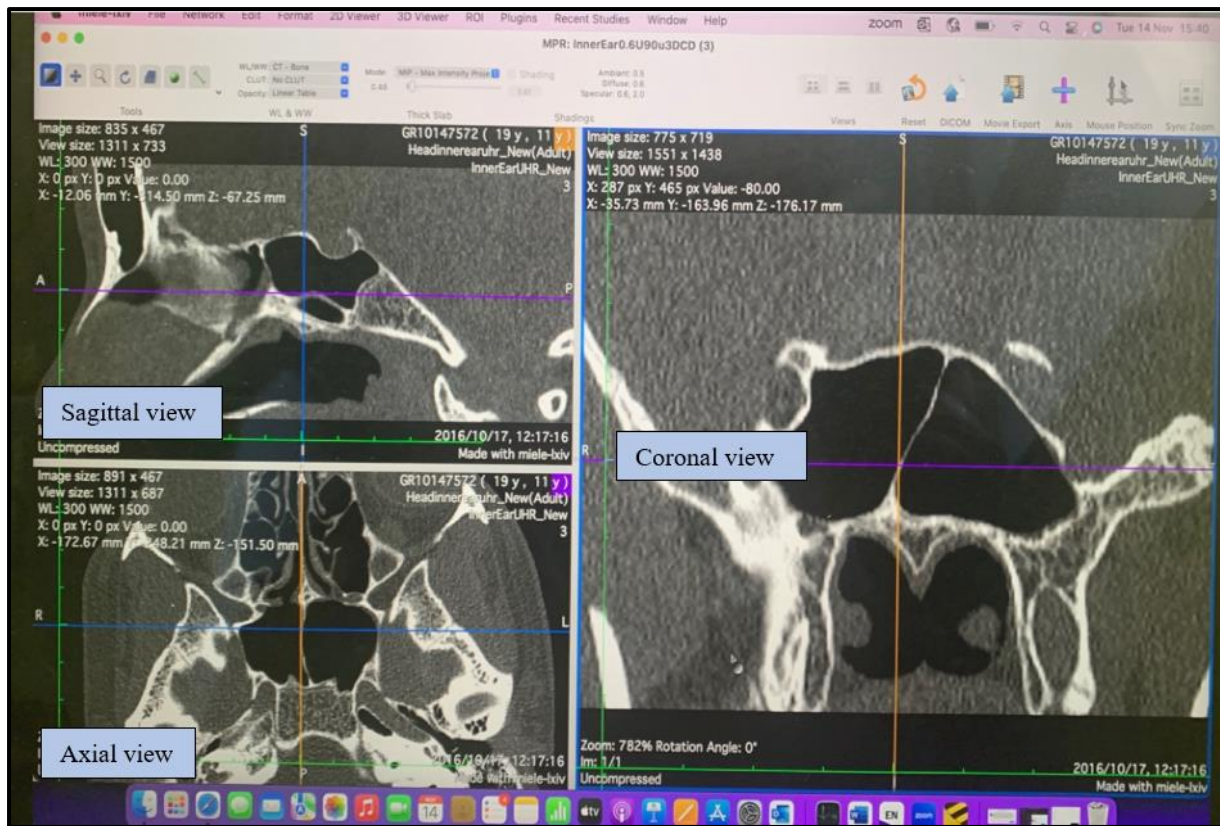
Mielie viewer software used to analyse CT scans.
